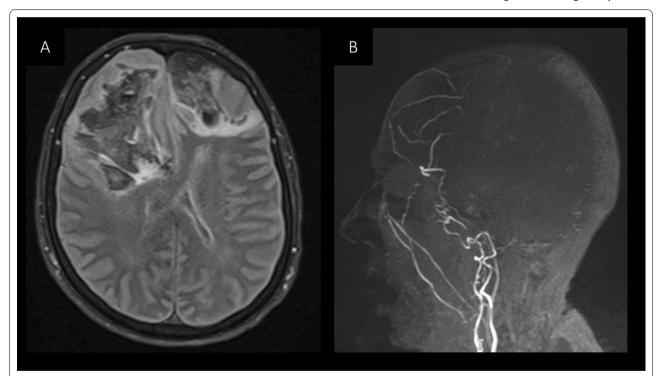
Cerebral venous thrombosis with bilateral frontal intraparenchymatous hemorrhage. A T2 FLAIR sequencing revealed bilateral left $(80 \times 53 \text{ mm})$ and right $(56 \times 23 \text{ mm})$ intra parenchymatous frontal hemorraghe. B Venous phase contrast MRI study showed an absence of venous blood flow in sigmoids and superior sagittal sinus
